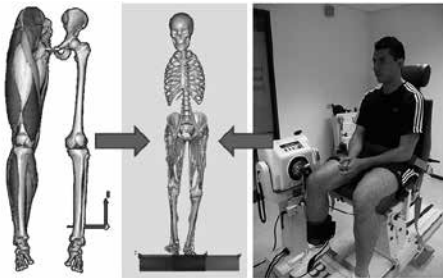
Subject-specific musculo-skeletal model (center) based on segmented MRI scan (left) and dynamometer tests (right).
